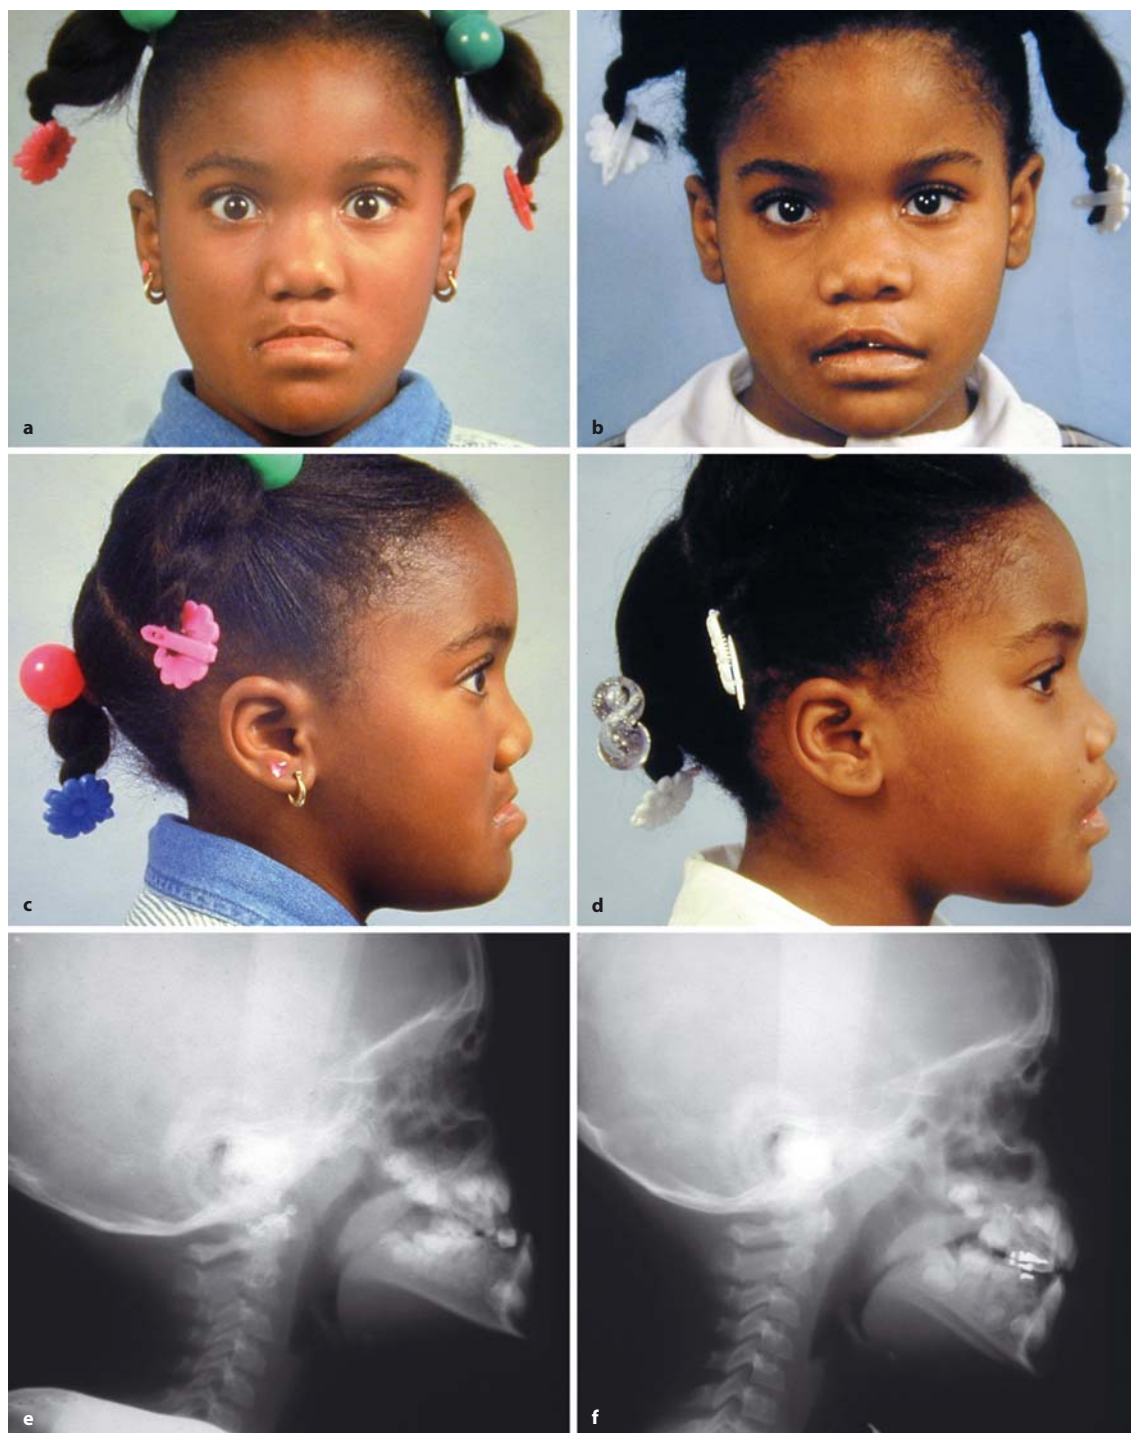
6 a-f. Six-year-old girl with left unilateral cleft lip and palate and severe maxillary hypoplasia. Predistracted (*left*) and postdistracted (*right*) facial and cephalometric radiograph views demonstrate correction of facial concavity and crossbite
